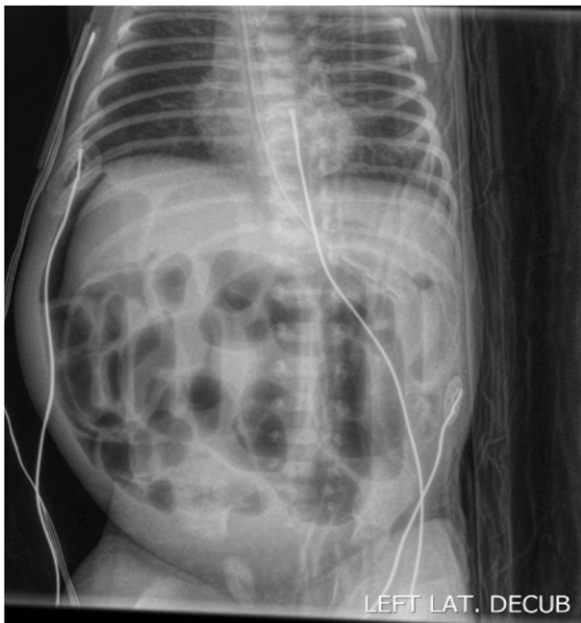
Abdominal radiograph on postnatal day 5, showing free intra-abdominal air.
